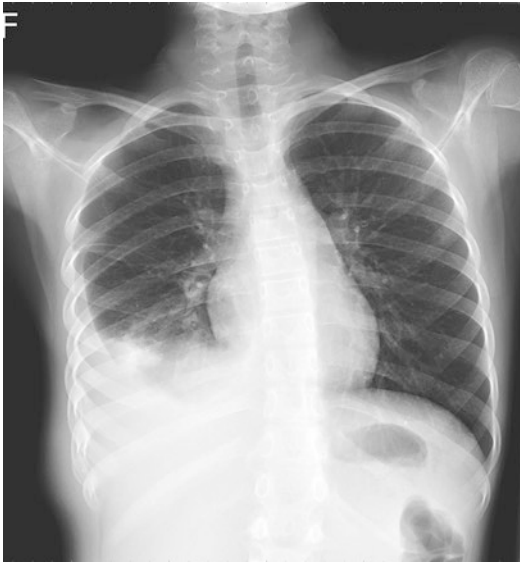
Chest X-ray film in a local hospital showed right lower lung consolidation with pleural effusion
